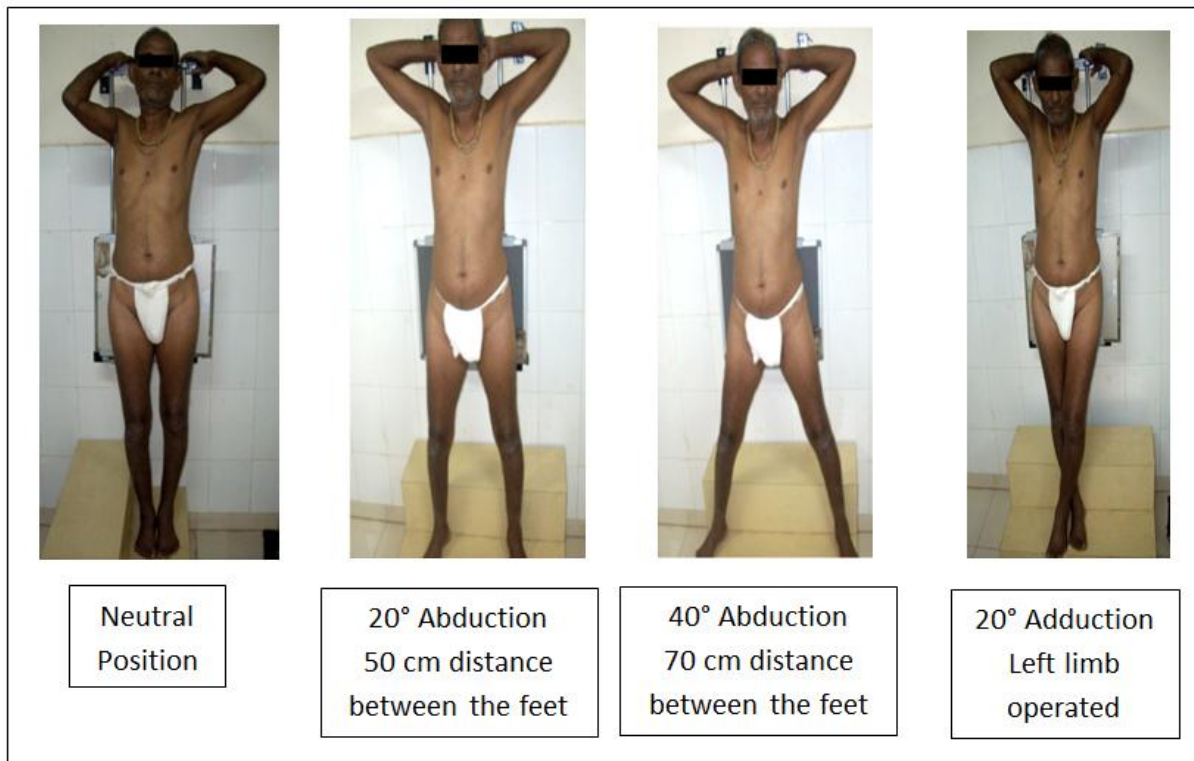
Lower Limb position while taking X-ray PBH AP view
